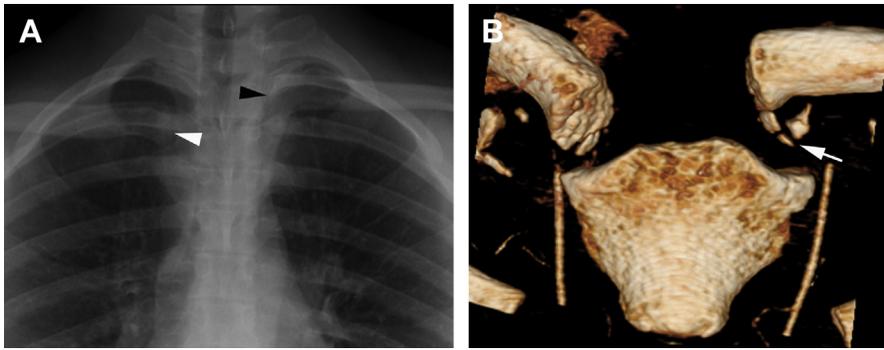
(A) A 17-year-old boy with concern for sternoclavicular dislocation after trauma. The left clavicular head (*black arrowhead*) is asymmetric and projects higher than the right (*white arrowhead*). (B) Three-dimensional reconstruction from a computed tomography scan demonstrating a Salter II fracture through the proximal left clavicle on same patient, with the epiphysis and small metaphyseal fragment (*arrow*) maintaining alignment with sternoclavicular joint with superior displacement of the left clavicle.
